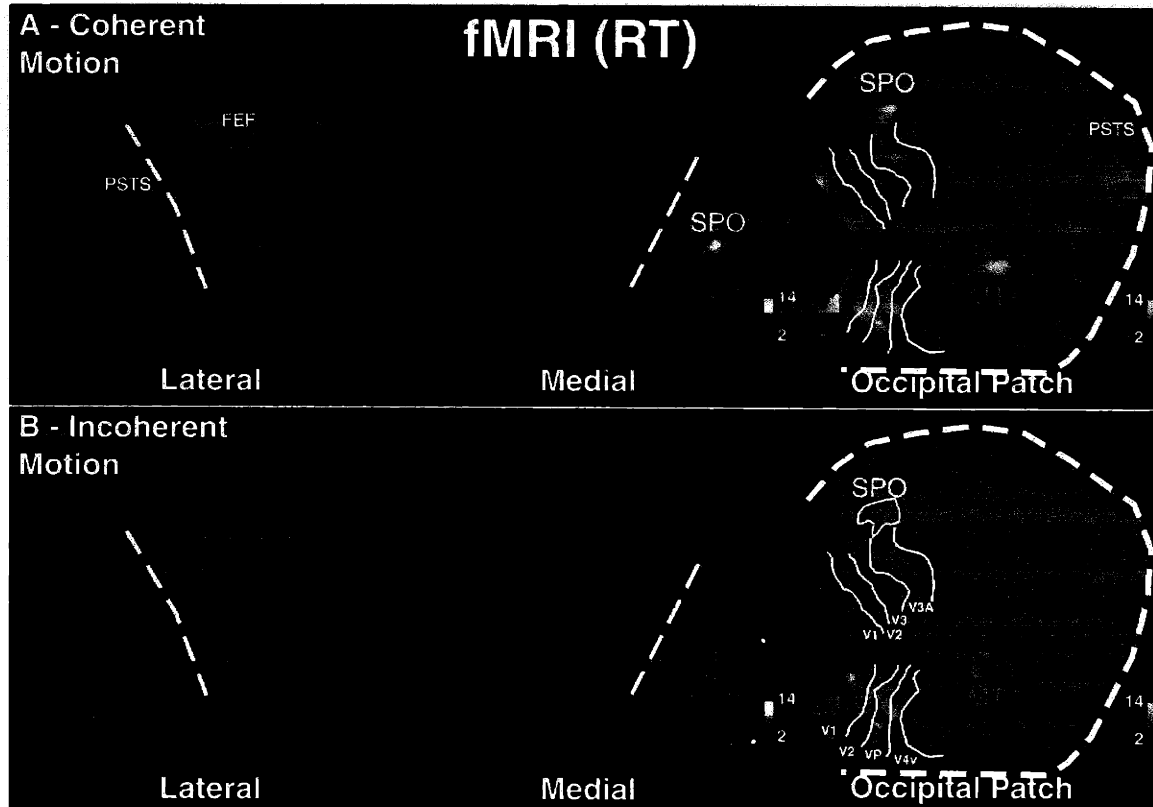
Functional MRI localization of coherent motion versus a stationary dot pattern (A) and incoherent dot motion versus a stationary dot pattern (B). The statistical maps of activation are displayed on the lateral and medial aspects of the inflated cortical surface (left) and the flattened occipital cortex (right). Sulci are shown as dark grey, and gyri are shown as light gray. The cortical inflation and flattening procedures are described in (7, 9, 10).
